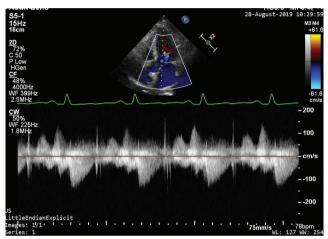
Transthoracic echocardiography color Doppler imaging showed a normal left ventricular outflow tract gradient after treatment.
